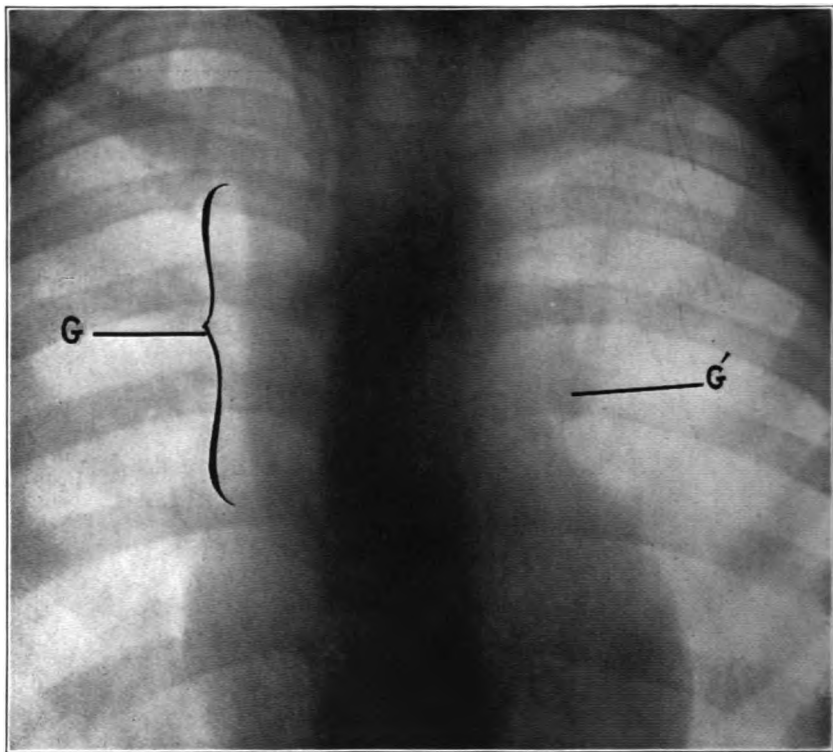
A. H. (209), aged 11. Retraction above right clavicle, and diminished expansion at right apex. Dilated veins over the front of the chest. Tender over fifth thoracic vertebra, less so over the upper four thoracic spines. Dulness to the fifth thoracic vertebra. Vertebral bronchophony, negative when first examined but later well marked. Tuberculin test negative. X-ray diagnosis: Normal markings of lungs show distinctly. Heart normal in size and position. Deficient aeration of and mottling of right apex. Enlarged bronchial glands, extending from the first to the third rib on the right (G), and on the left, opposite the cartilage of the second rib (G').
